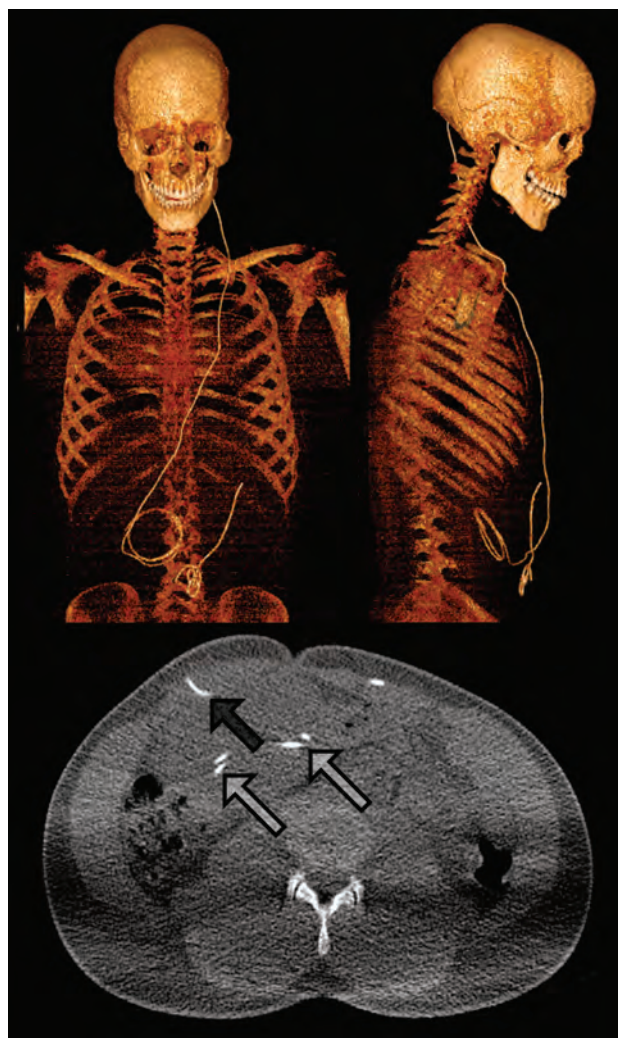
As a premature infant, a 19-year-old man developed intraventricular hemorrhage grade IV with consecutive posthemorrhagic hydrocephalus and formation of a left frontal intracranial cyst. A cysto-ventriculoperitoneal shunt was implanted during the first months of life. At 19 years of age, the patient was referred to our center because of abdominal pain and local induration around the right abdominal scar. WB-ULD-CT revealed an intraperitoneal position of the distal catheter, however with an intraperitoneal cyst or pseudocyst formation. Front (upper left) and lateral (upper right) views of the 3D reconstruction show looping of the peritoneal catheter. On the axial conformation with 5-mm section thickness, intraperitoneal insertion of the catheter (full arrow) as well as intraperitoneal pseudocyst with incorporated catheter loops (transparent arrows) can be detected.
